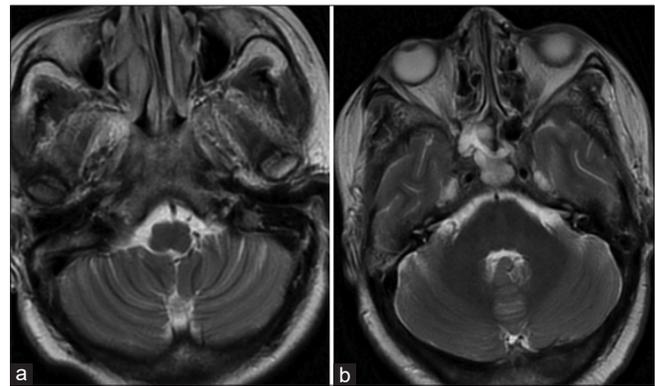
(a and b) Postoperative MRI scans with axial sections at the level of cerebellum showing no evidence of infarction following the injury to the left-sided vertebral artery.
